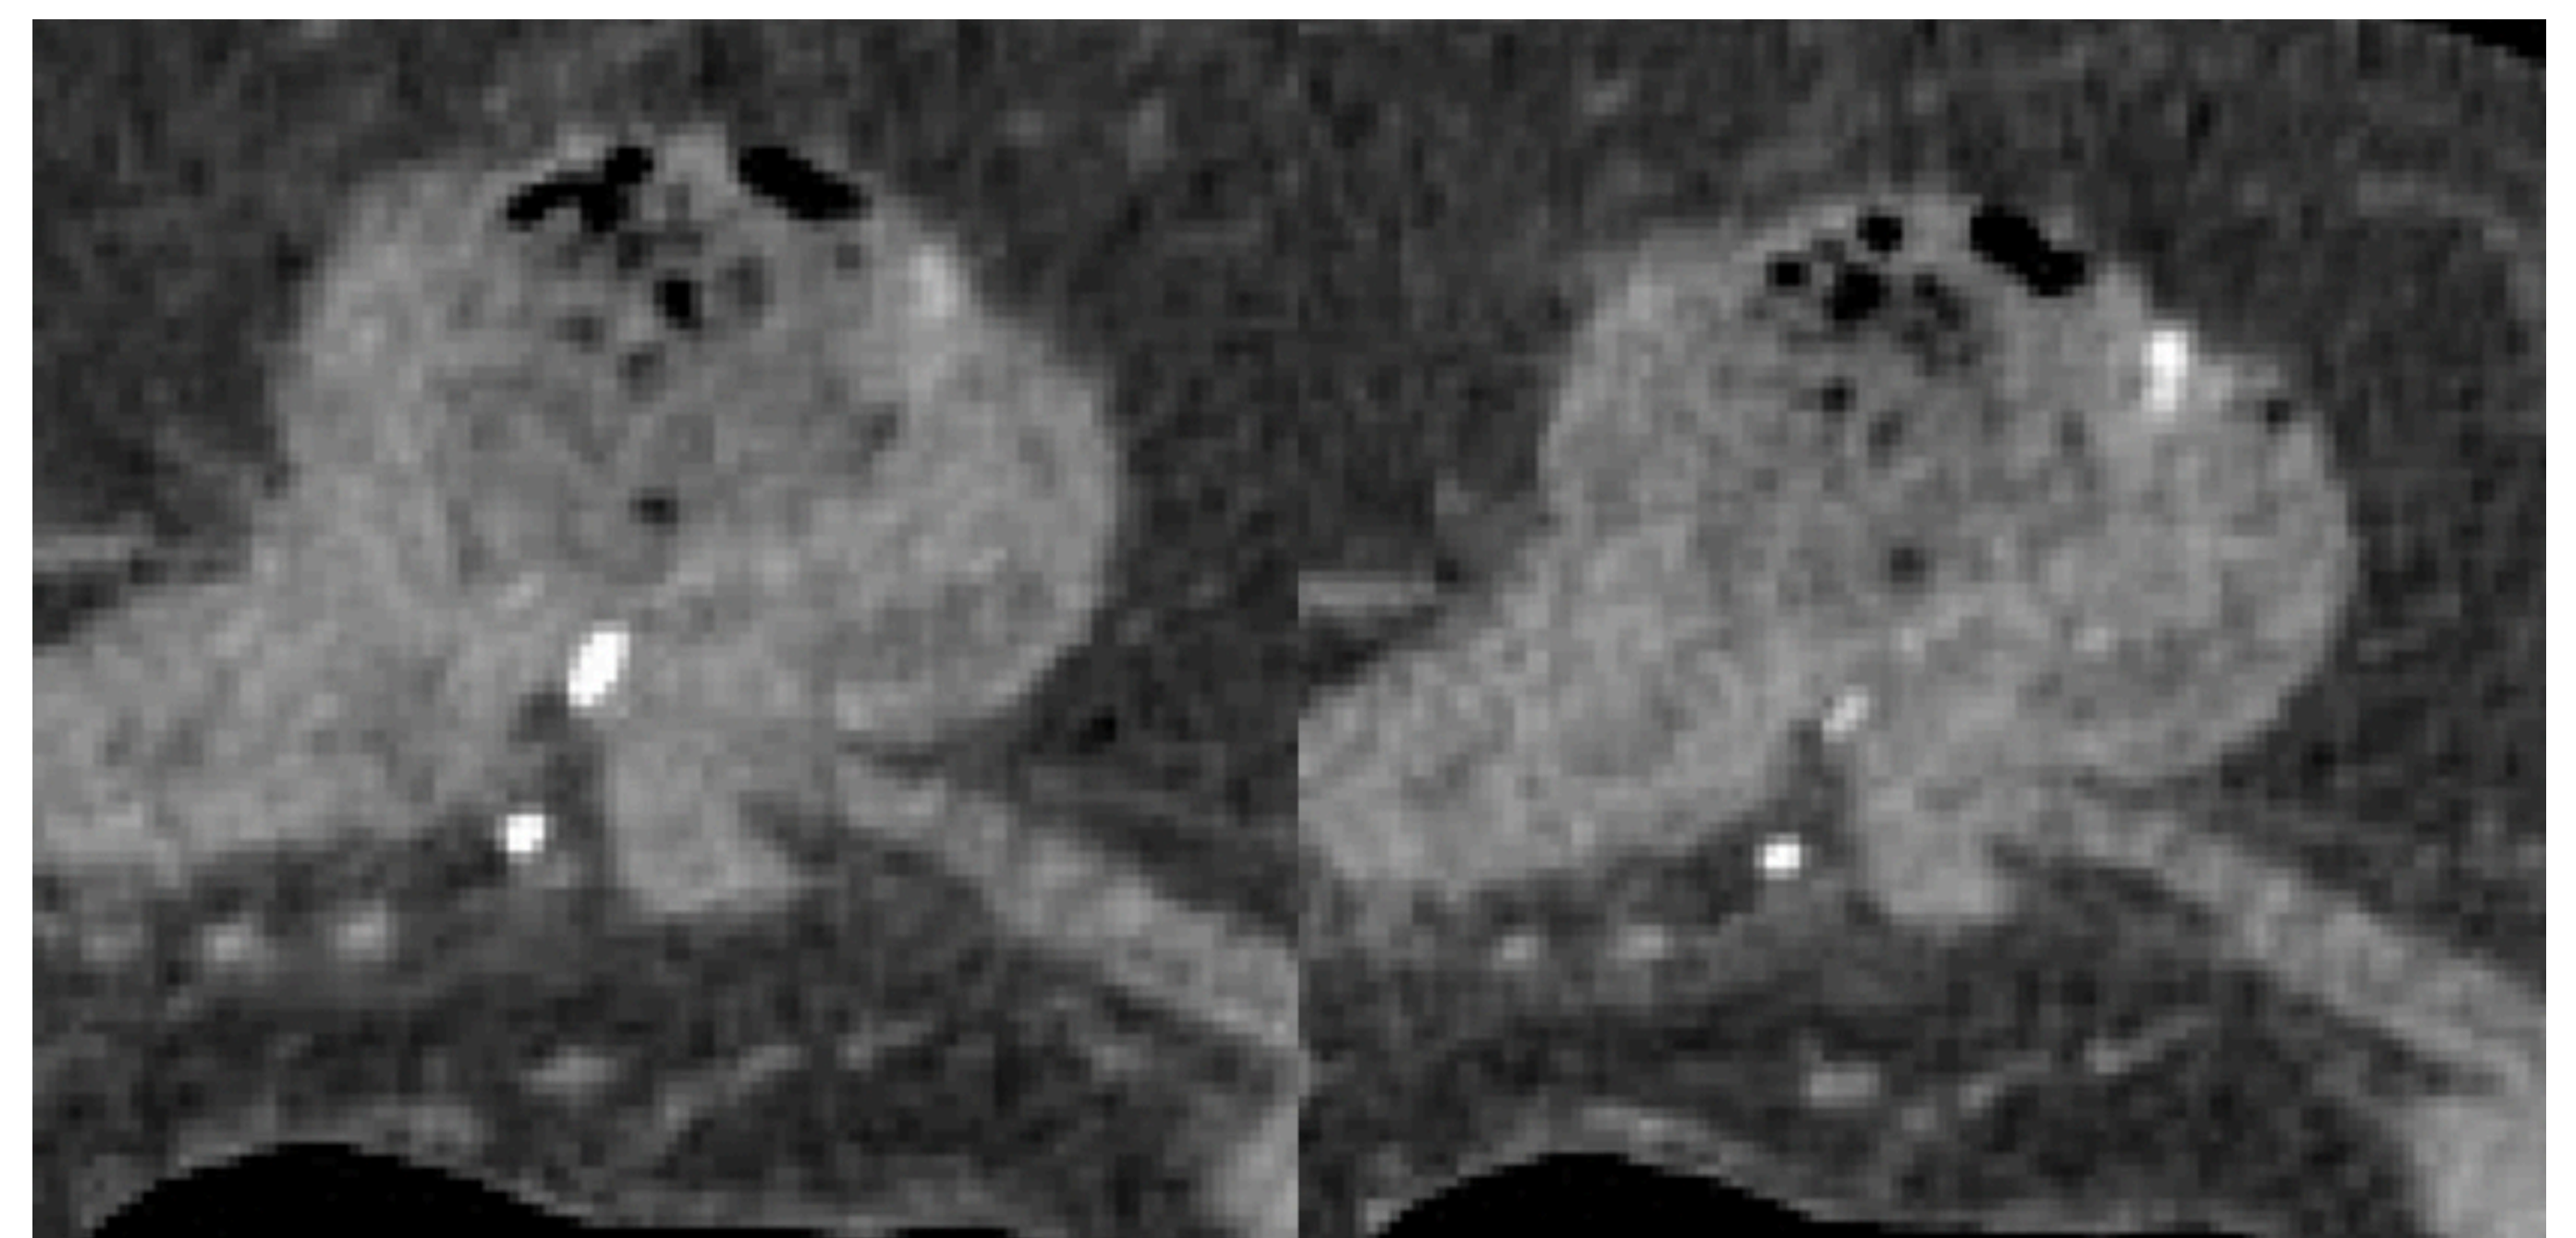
CT image showing the JJ anastomosis within the incisional hernia sac
